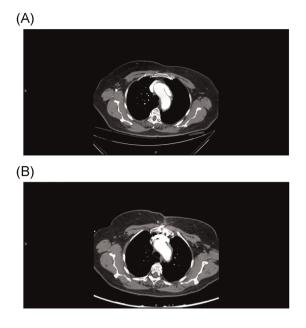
Computed tomography angiography showing the type A aortic dissection pre-op (A) and post-op (B) in axial view
